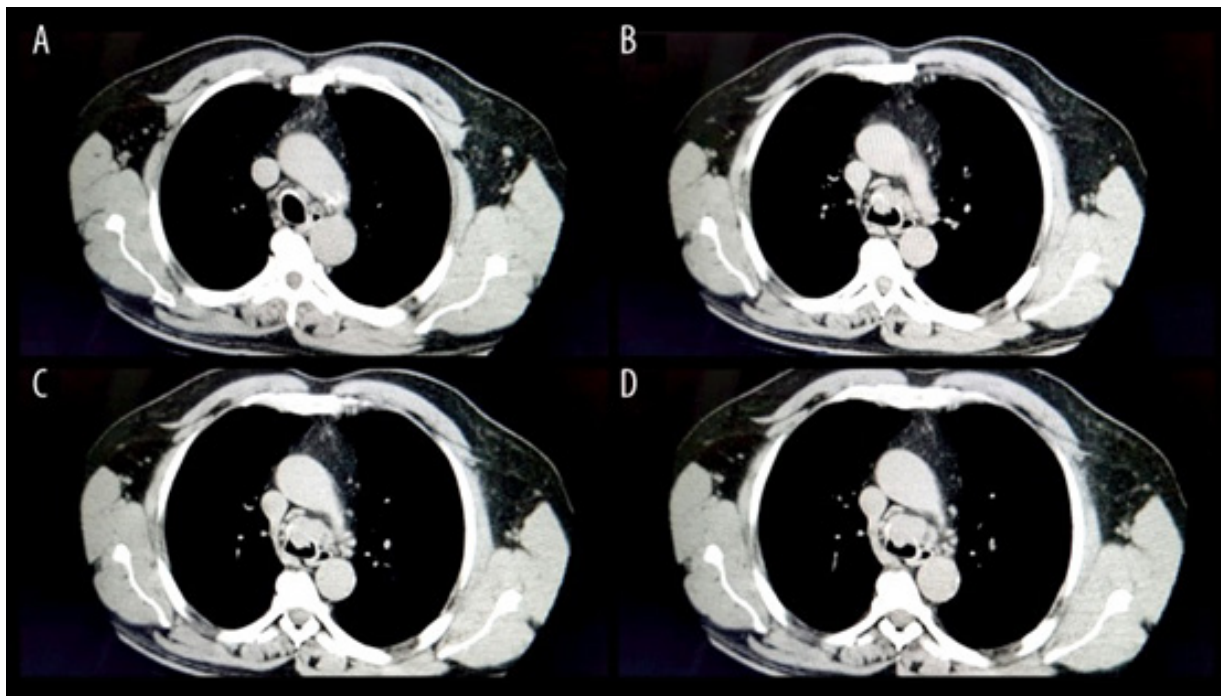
Computed tomography scan of the chest revealed the lesion in the trachea.
